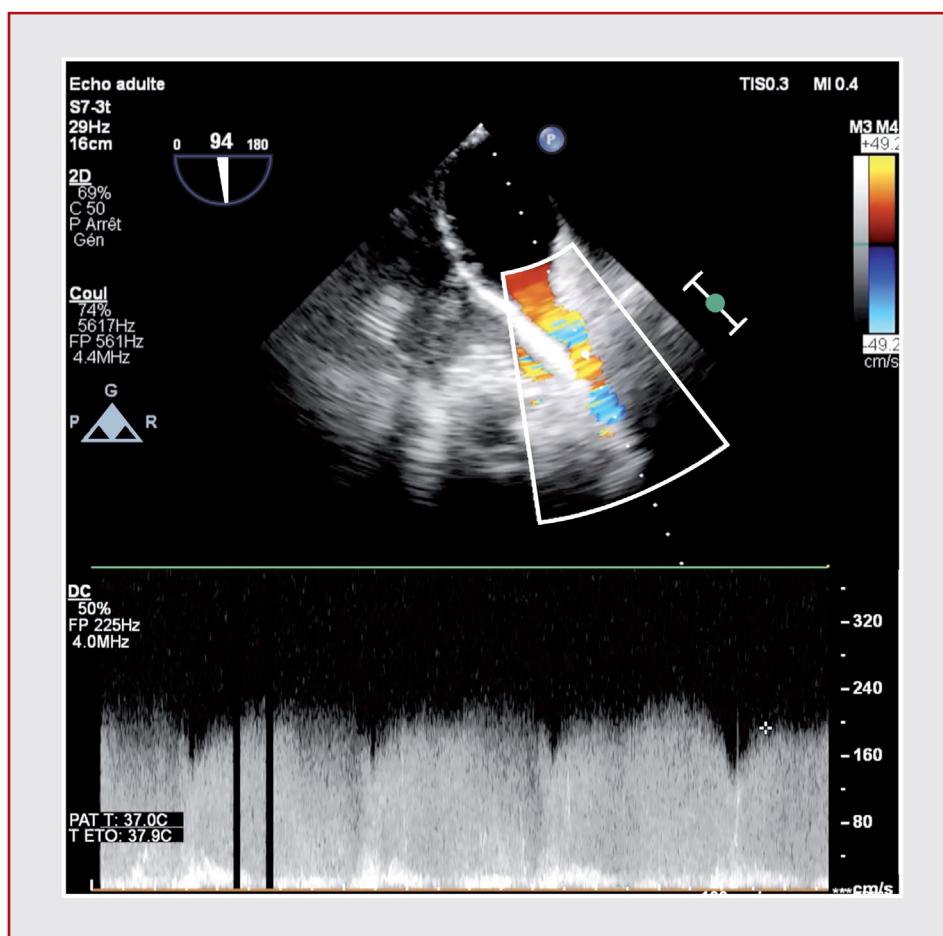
Superior vena cava (SVC) acceleration following Warden surgery for partial anomalous pulmonary venous connection. Upper section: acceleration of SVC with colour-flow Doppler; deep transgastric modified view. Lower section: continuous Doppler scan of SVC acceleration.
